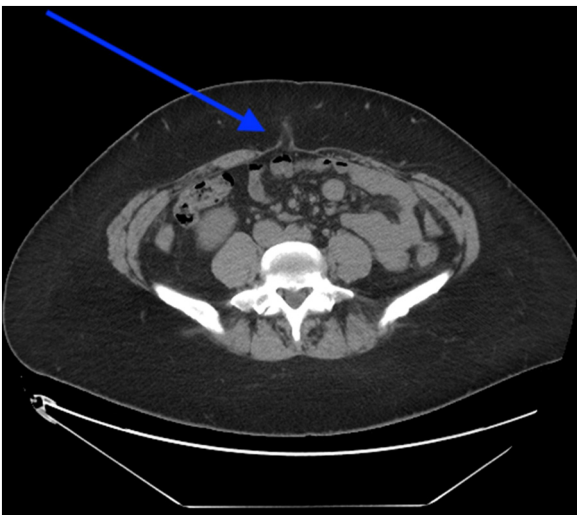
CT scan axial view of the umbilical hernia (blue arrow).
